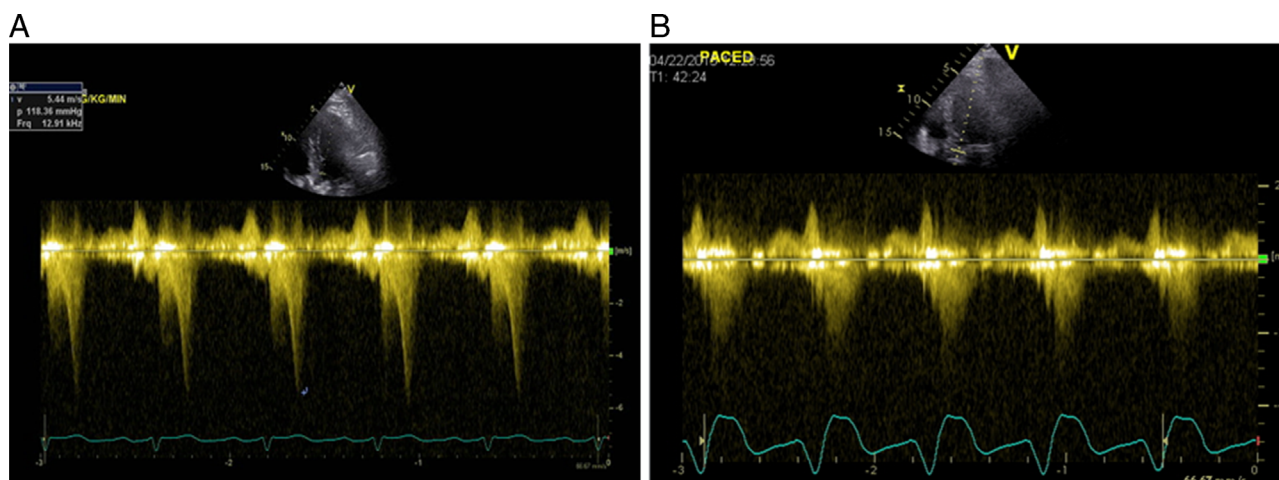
A: During infusion of dobutamine (5 mcg/kg/min) with a rate just under 1-bpm, a mid left ventricular gradient >100mm Hg is noted by continuous wave Doppler. B: During ventricular pacing at 100 bpm, there is complete resolution of the midventricular gradient.
